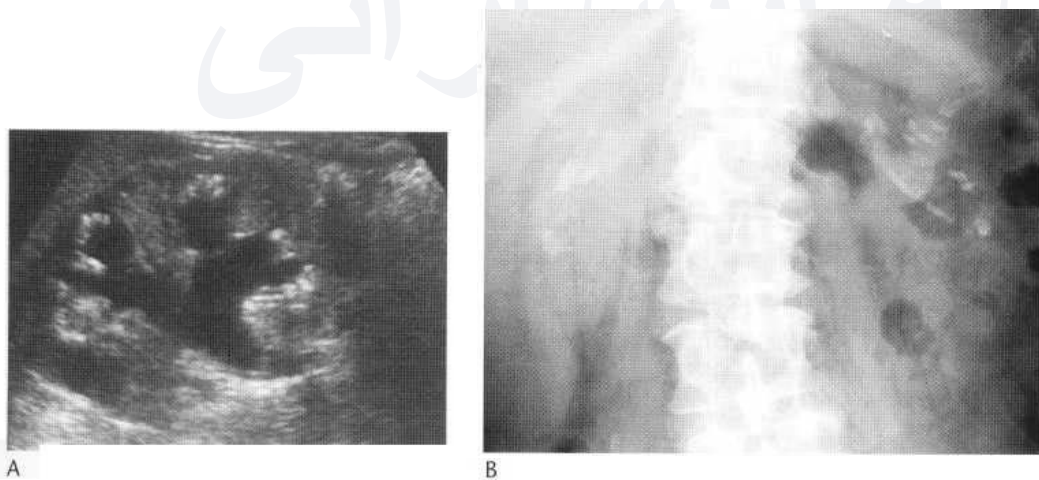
Ultrasound of a patient with medullary sponge kidney showing multiple small echogenic areas in the papillae due to tiny calculi in the collecting duct (A). There is also hydronephrosis and proximal hydronephrosis due to a ureteric calculus. Plain film nephrocalcinosis (B) in a different patient.
